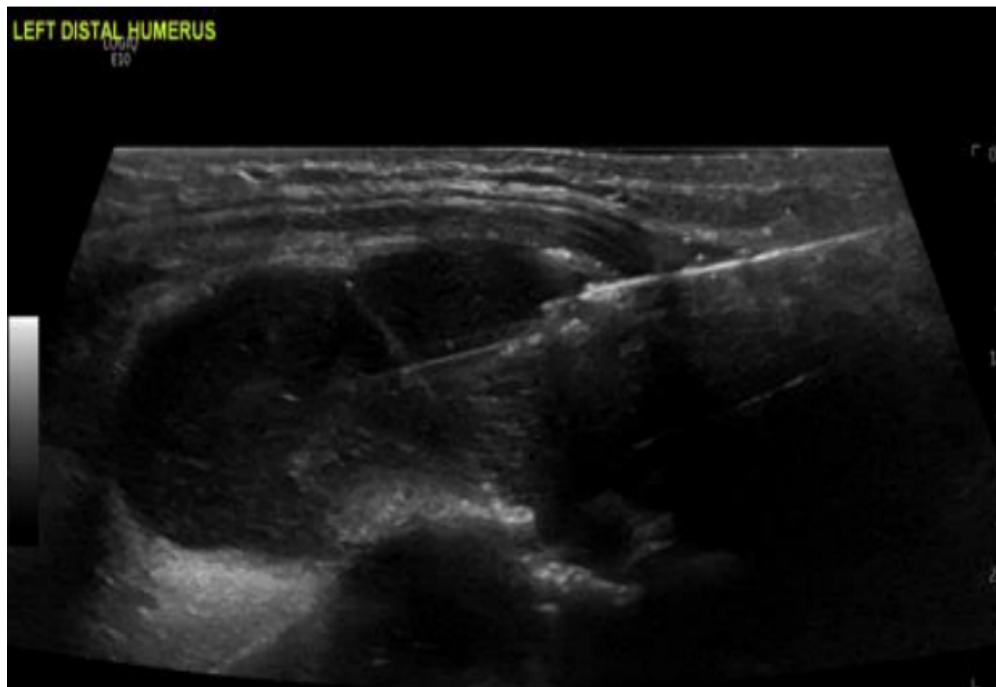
Image from ultrasound-guided biopsy shows the coaxial biopsy needle within a well-defined lobulated hypoechoic lesion next to area of irregular bone cortex.
